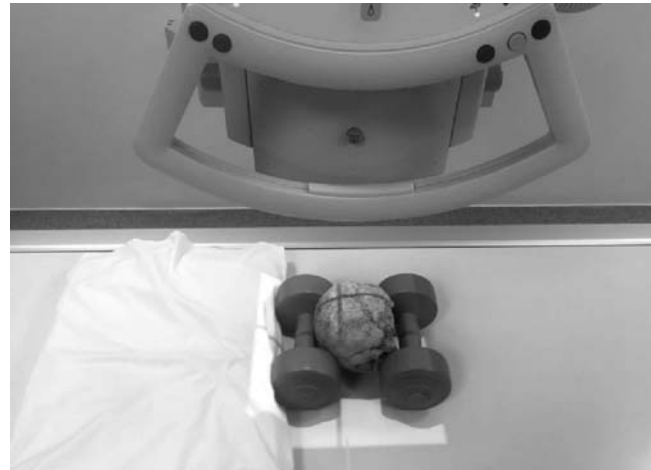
Cranium positioned similar to Caldwell's view against X-ray detector.
